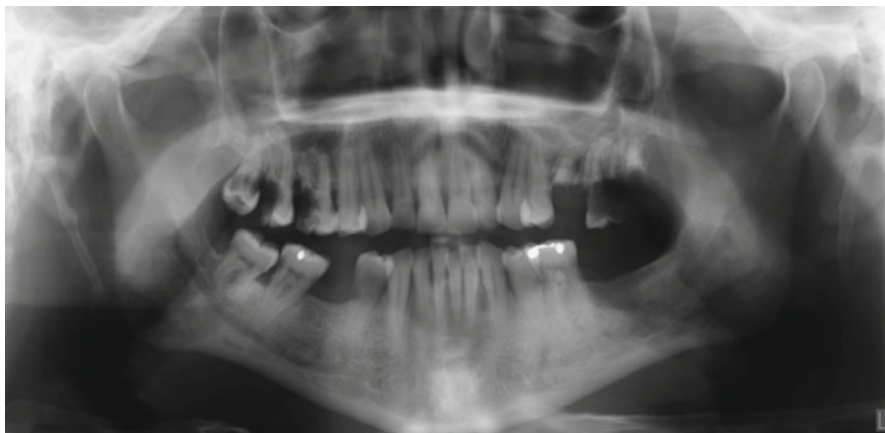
Panoramic radiographs are an excellent screening tool to determine anatomic landmarks and the degree of difficulty of the extraction
